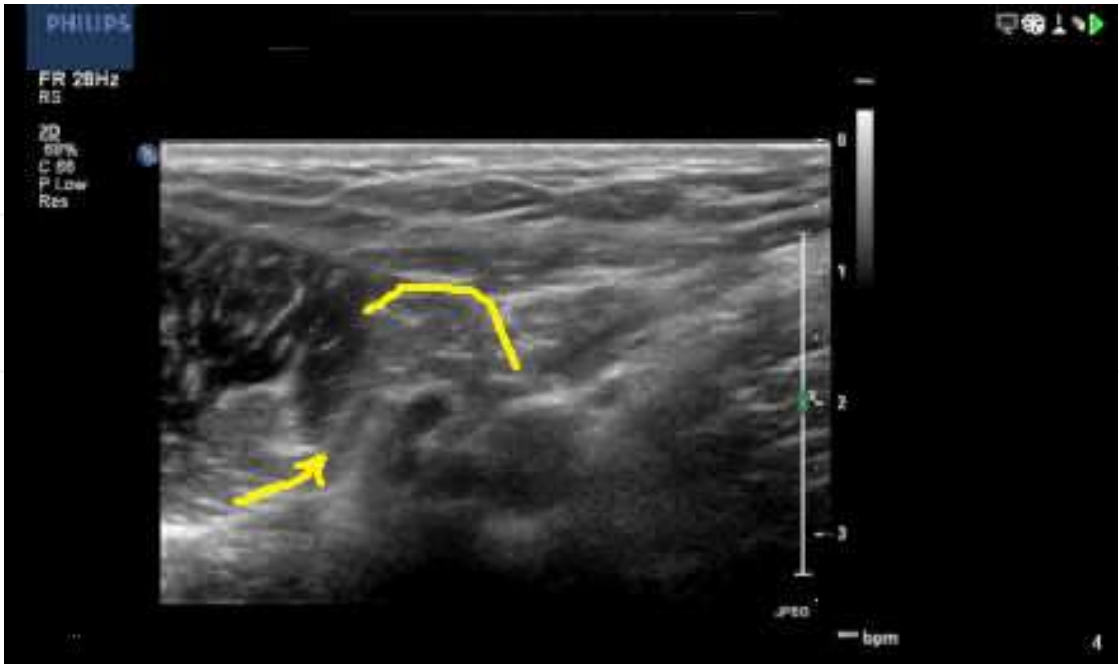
Posterior inguinal wall deficiency can be demonstrated sonographically
